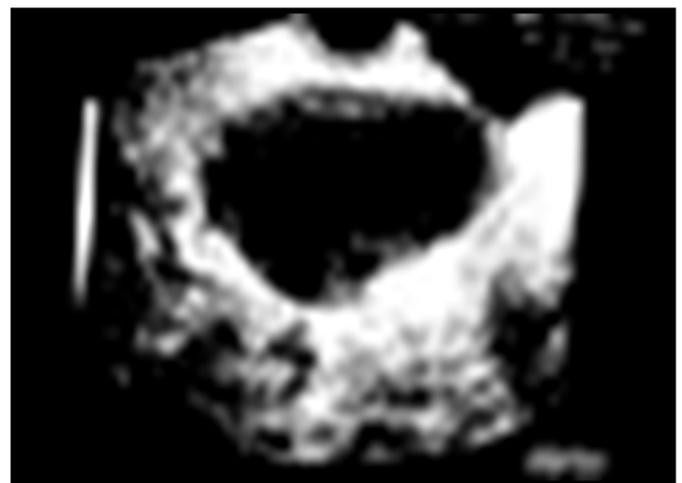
Transvaginal ultrasonographic imaging of ovarian thecoma, (our case).
